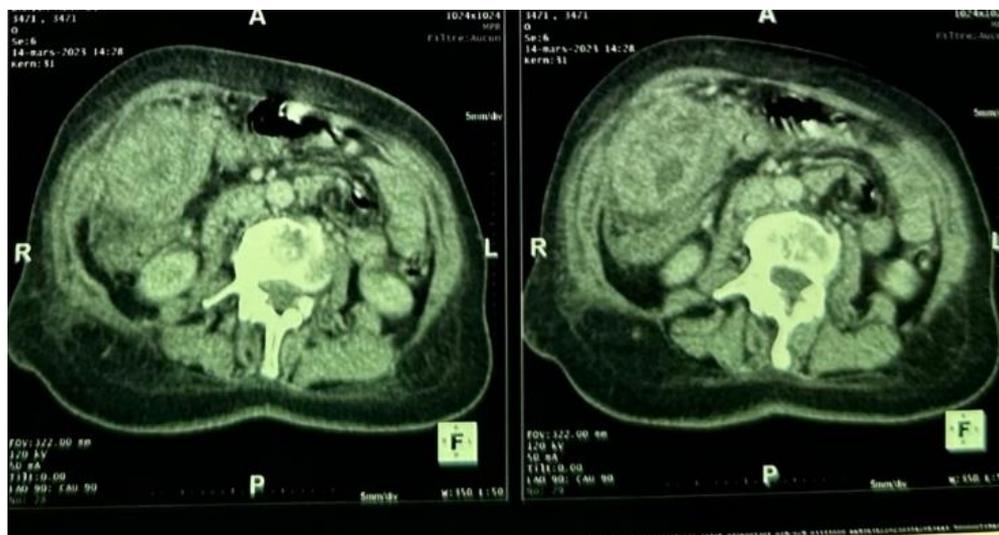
CT scan of the lesion
